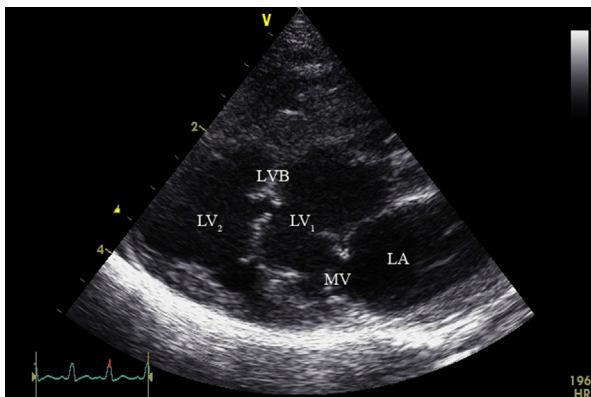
A right-parasternal long-axis four-chamber echocardiographic image showing a band of tissue extending from the LV free wall to the interventricular septum approximately midway between the origin of the papillary muscles and the basal attachments of the mitral valve. The band of tissue is perforated in the center. LA, left atrium; MV, mitral valve; LV₁, basal portion of left ventricle; LVB, left ventricular band; LV₂, apical portion of left ventricle.
